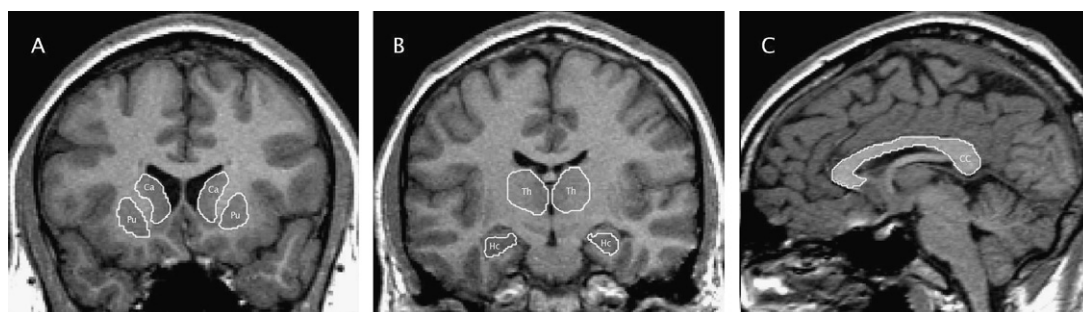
MRI regions of interest. (A) Caudate (Ca) and putamen (Pu). (B) Thalamus (Th) and hippocampus (Hc). (C) Corpus callosum (CC).
